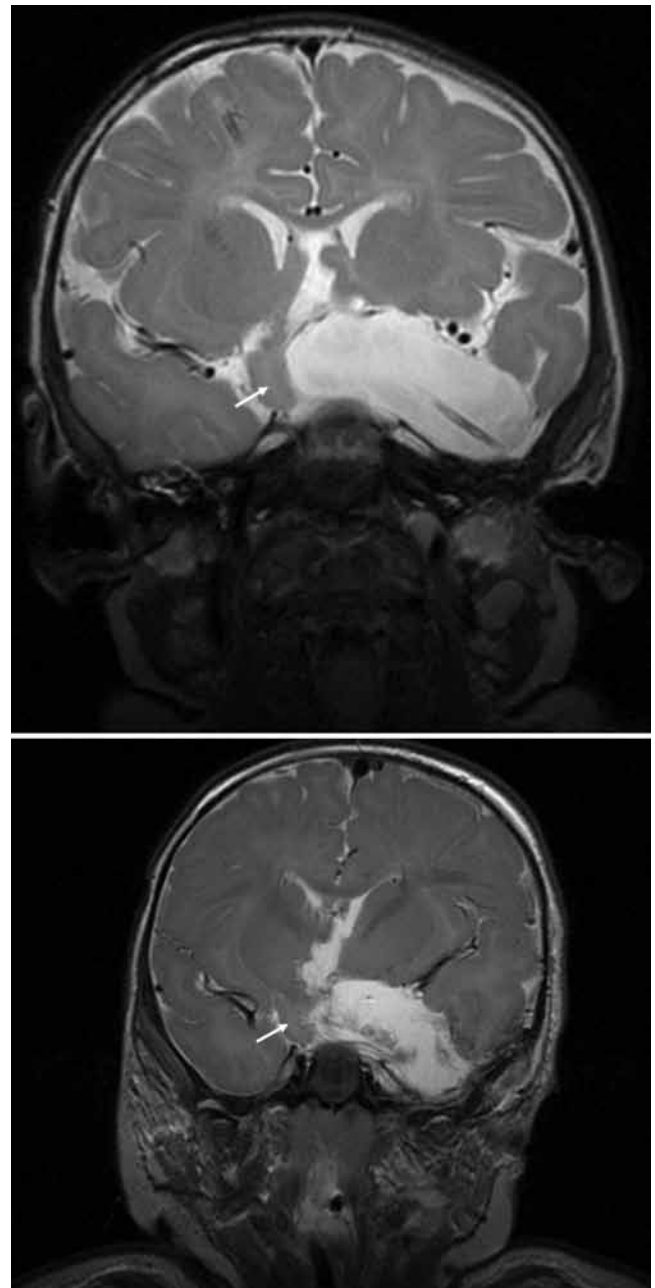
Case 3. Upper: Coronal T2-weighted brain MR images obtained shortly after left orbitozygomatic resection of most of the HH (with drain tube in situ) and before arachnoid cyst fenestration. Arrow points to residual HH tissue on the right. Lower: Coronal T2-weighted brain MR image obtained after arachnoid cyst fenestration with resultant relief of mass effect. The residual HH is shown by the arrow.
